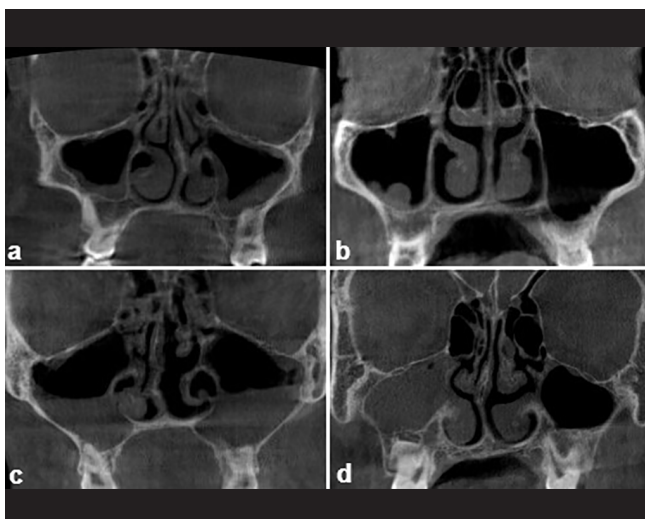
Maxillary sinus pathologies on coronal CBCT images: a) ethmoid sinusitis and mucosal thickening localized in the right maxillary sinus, generalized mucosal thickening in the left maxillary sinus; b) polypoidal mucosal thickening in the right maxillary sinus; c) ethmoid sinusitis and partial opacification in the right and left maxillary sinuses; d) total opacification in the right maxillary sinus.
